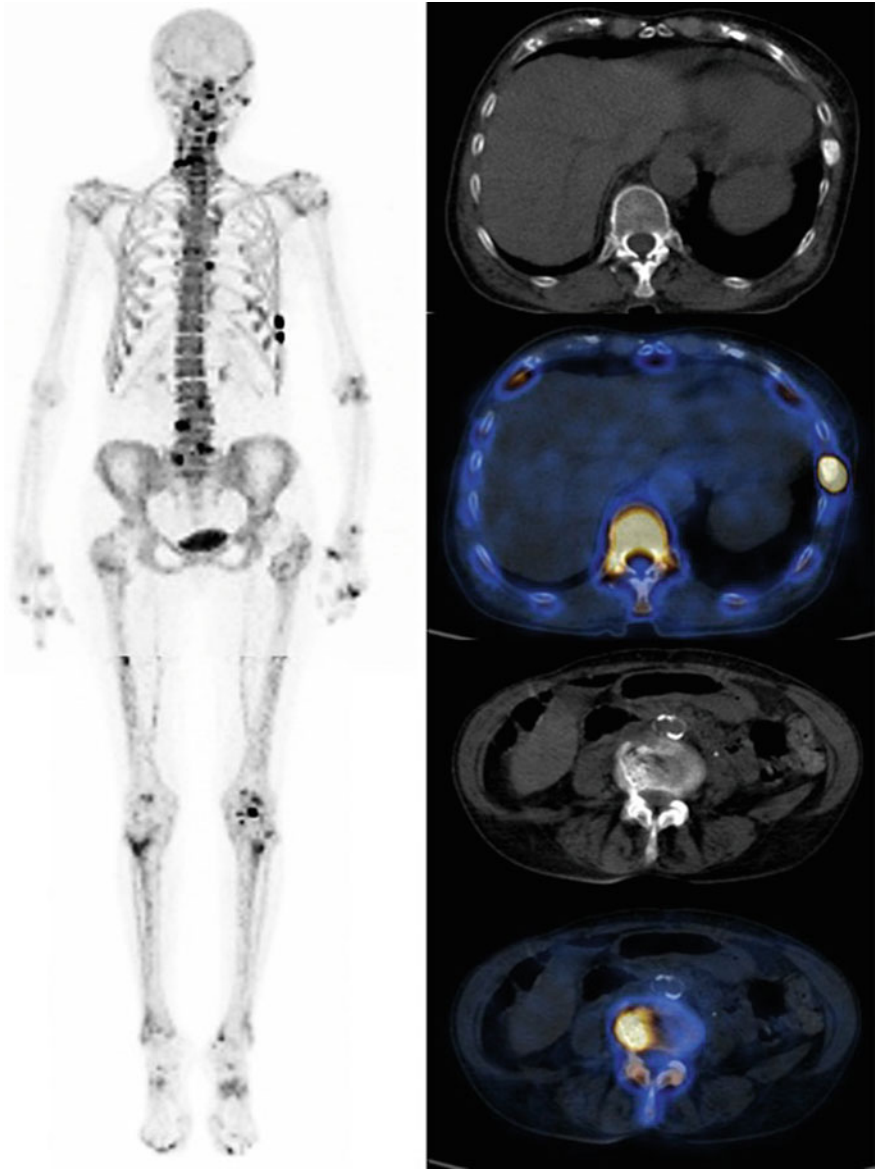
MIP image of ^{18}F -Fluoride PET/CT (left-sided panel of the figure), with axial images of a patient referred for suspicious bone metastases from breast cancer; no clear malignant lesions were documented, however the patient presented with diffuse degenerative alterations and left-sided rib fractures (axial views on the right panels)
